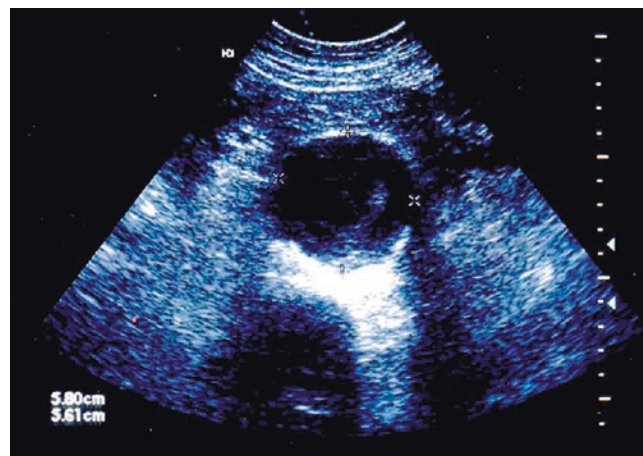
Duplex ultrasonography documenting an abdominal aortic aneurysm
